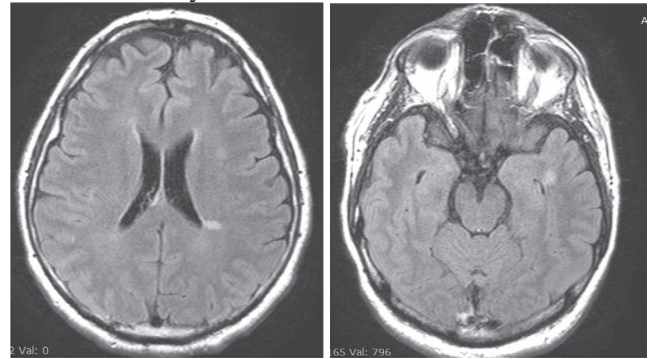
Brain and spinal MRI of MS-AS patients in case 1 and case 3.
